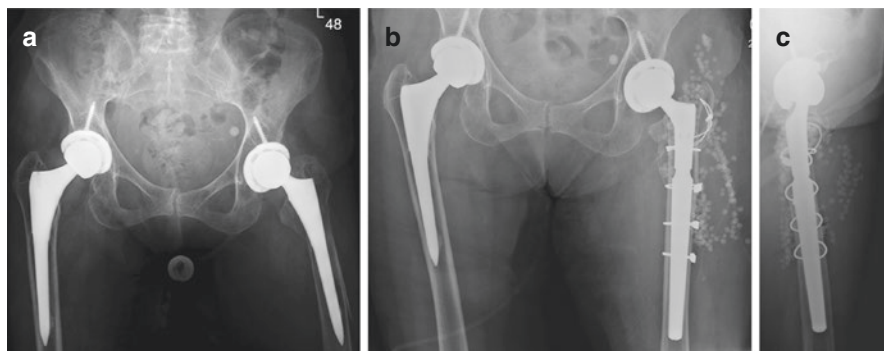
(a) Anteroposterior (AP) radiograph of a 92-year-old female patient with a history of bilateral THA demonstrating a left Vancouver Type B2 periprosthetic fracture which occurred after a ground-level fall; (b, c) AP and lateral radiographs demonstrating a revision arthroplasty with a modular fluted tapered stem and cable fixation. Note an extended trochanteric osteotomy was used for removal of the index femoral component
